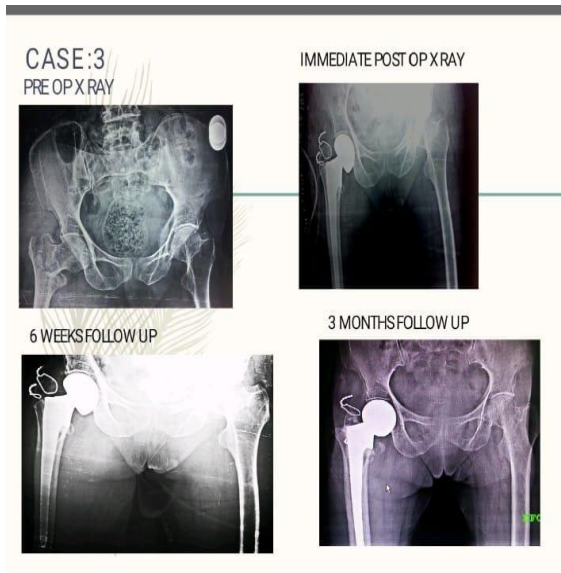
Case 3 pre-operative X ray and post-operative x-ray, 3- & 6-month follow-up x ray
